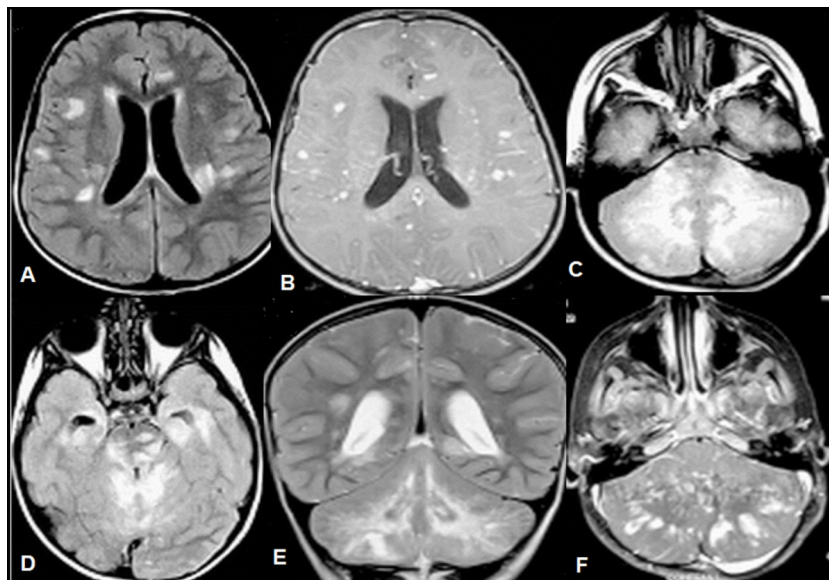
Magnetic resonance imaging of the brain in patient 1. (A) Fluid-attenuated inversion recovery axial view demonstrating multifocal white matter hyperintensities involving periventricular, deep- and sub-cortical white matter. (5 mm thick, repetition time = 9000 ms, echo time = 119 ms, inversion time = 2457 ms, matrix of 256 × 256, field of view = 230 mm). (B) On contrast-enhanced T1-weighted images the lesions show intense contrast enhancement. (Repetition time = 650 ms, echo time = 14 ms, acquisition time of 2.5 mt, matrix of 256 × 256 and a 230 mm field of view). (C) T2-weighted (Repetition time = 4000 ms, echo time = 120 ms) axial and coronal images (C and E) and fluid-attenuated inversion recovery (Repetition time = 9000 ms, echo time = 119 ms) axial image. (D) Signal changes in the brainstem, middle cerebellar peduncle, cerebellar white matter and dentate nuclei. On contrast, enhanced T1-weighted axial images the lesions show intense contrast enhancement (F).
